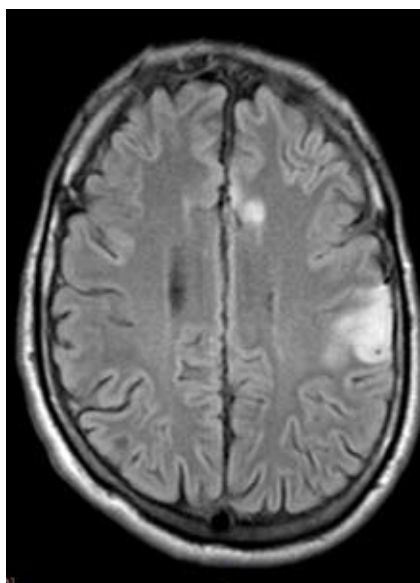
Brain magnetic resonance imaging (MRI) showing the ischemic lesions located frontally and frontoparietally (on the left).
